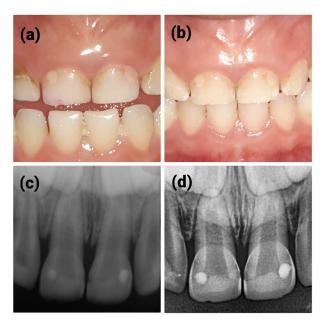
Clinical and Radiographic follow-up: a: Clinical follow-up after 3 months, b: Clinical follow-up after 6 months, c: Radiographic follow-up after 3 months, d: Radiographic follow-up after 6 months.
